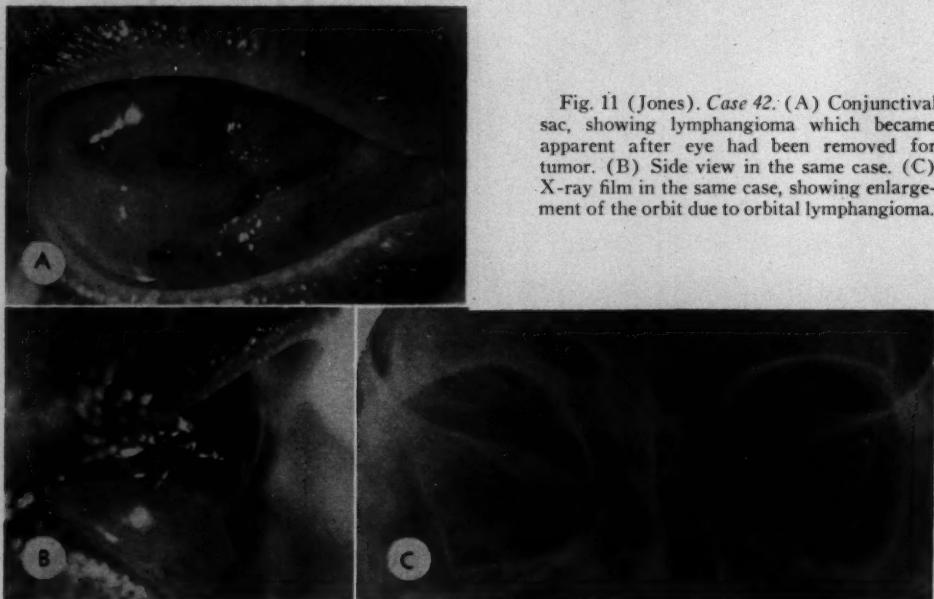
(Jones). *Case 42.* (A) Conjunctival sac, showing lymphangioma which became apparent after eye had been removed for tumor. (B) Side view in the same case. (C) X-ray film in the same case, showing enlargement of the orbit due to orbital lymphangioma.
